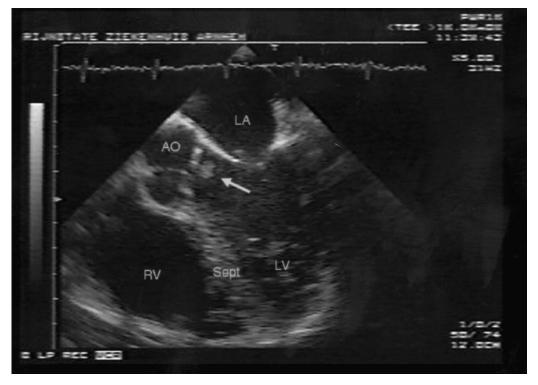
Transesophageal echocardiogram showing large (ca. 8 mm) vegetations on the left coronary cusp of the aortic valve of patient B.
